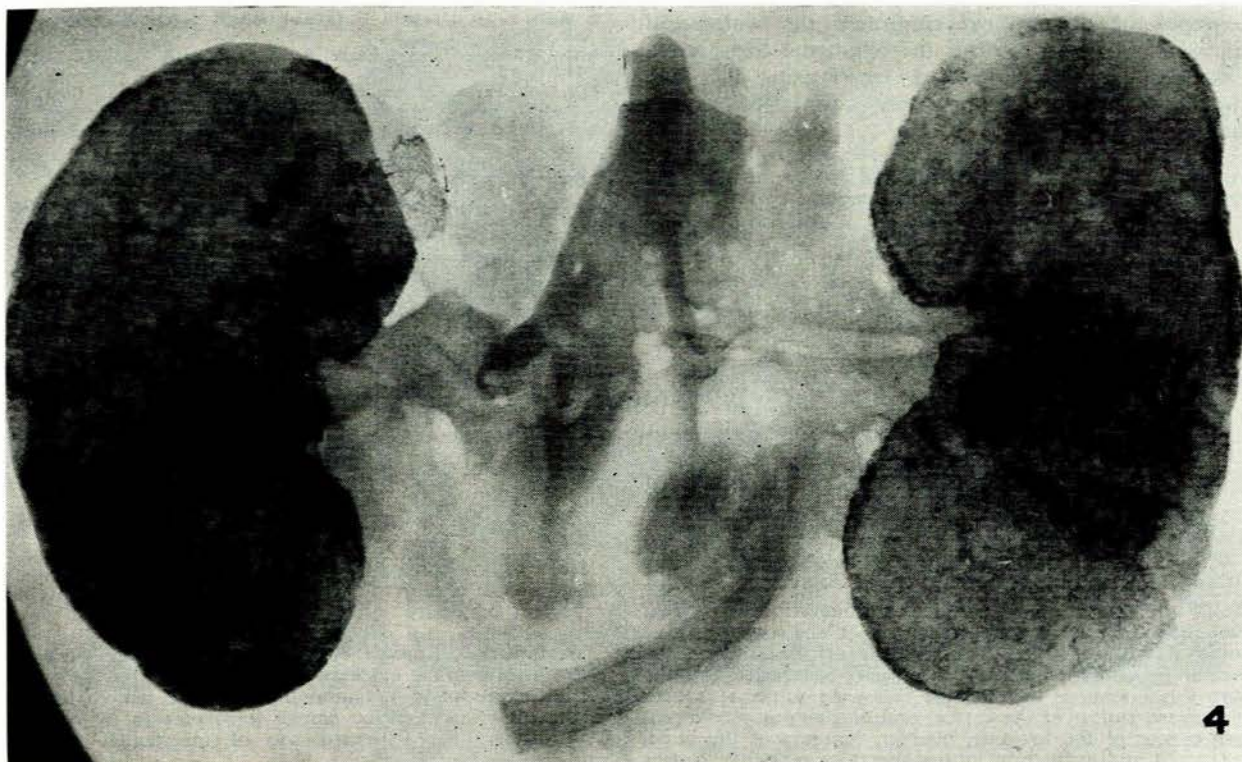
The postmortem radiograph. Extensive mottled calcification is present, but only towards the hilum is the tram-line pattern easily discernible.
